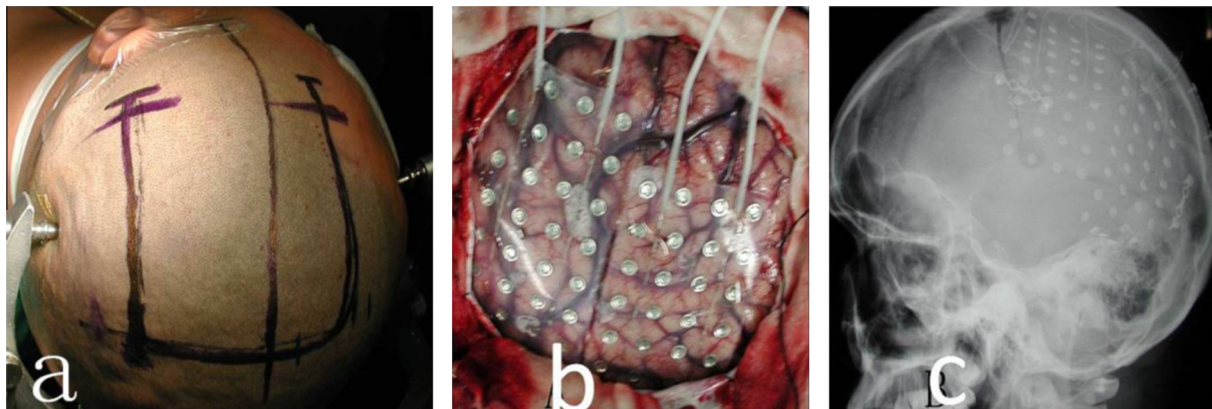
Perioperative photography showing (a) a rolandic skin flap, (b) axial view of the implantation of the electrodes at surgery, and (c) sagittal radiography showing the placement of the electrodes post-surgery.
